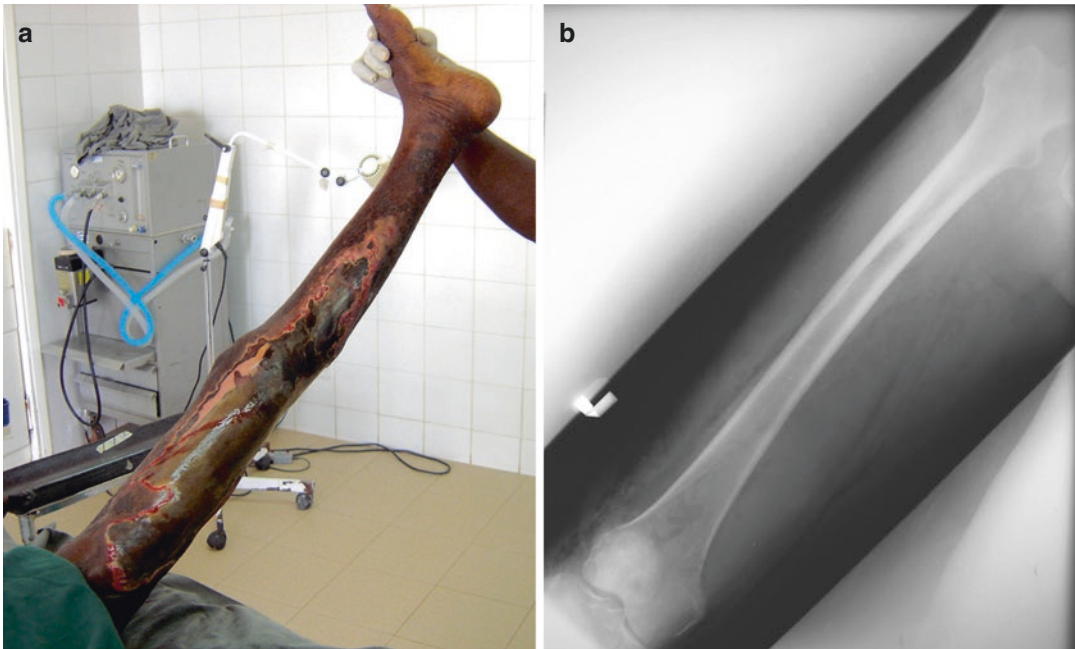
(a) Gas gangrene involving the entire lower extremity of the young male patient who died of sepsis shortly after hip disarticulation. (b) X-rays show gas in the soft tissues and dissecting between muscle planes
